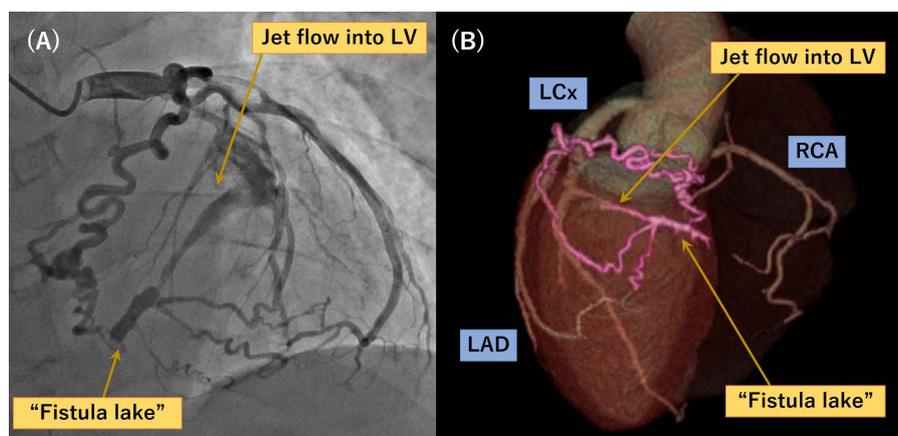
(A) Coronary angiogram showing multiple coronary arteries draining into the LV via a “fistula lake”; (B) Preoperative coronary computed tomography angiography showing the fistulous tracts that had converged to form a “fistula lake” and then entered the base of the LV posterior wall myocardium. LV, left ventricle.
